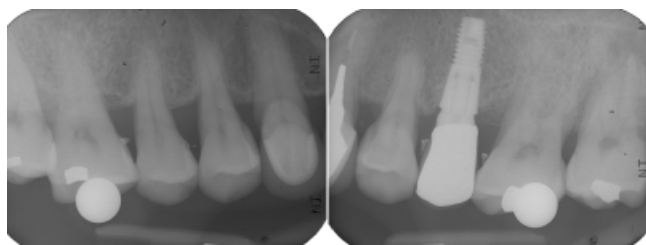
Periapical view with radiopaque material applied at the tip of the papilla.
